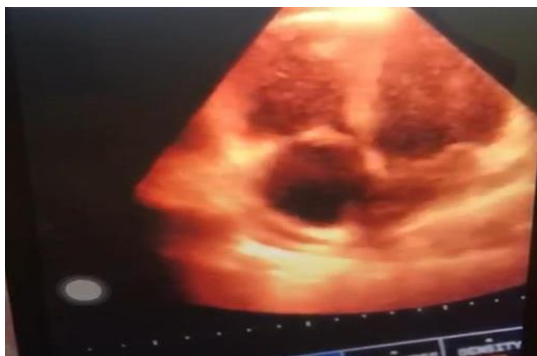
Apical four-chamber view showing free right atrium from the thrombus, 24hrs after starting treatment and also showing dilated right atrium and right ventricle
